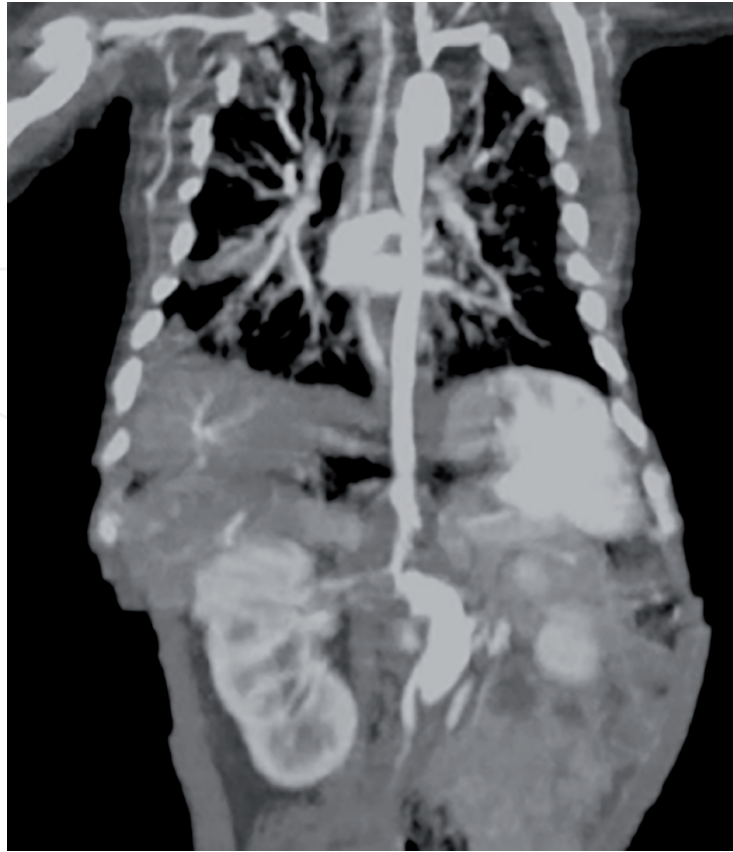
Vascular abnormalities in computed tomography, such as dilation of the abdominal aorta and stenosis of the renal artery [12].
